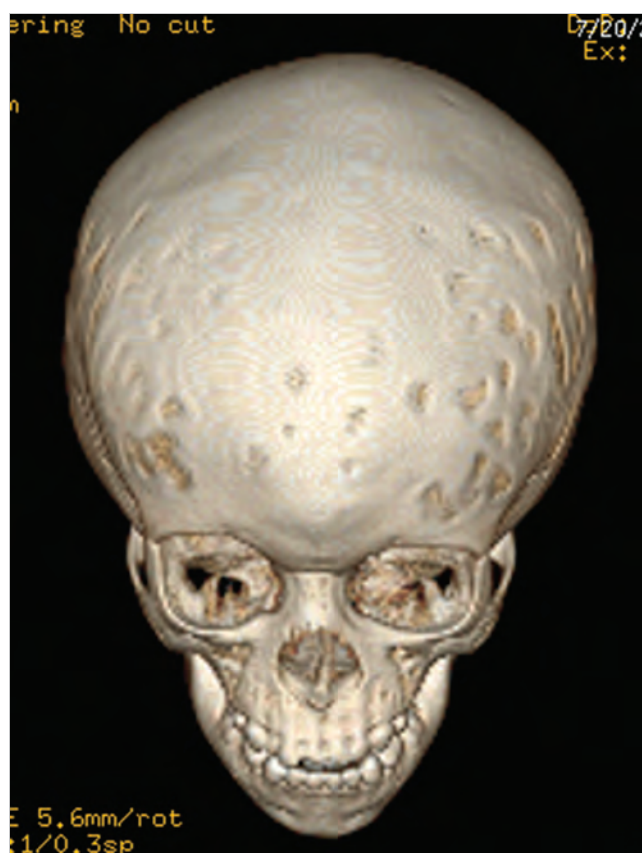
CT image of a 2-year-old child with progressive postnatal pansynostosis. Note absence of any suture definition and surface irregularities suggestive of bone thinning.
